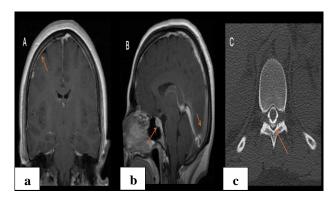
CSF leak-induced intracranial hypotension (a) post-contrast coronal T1 image shows smooth, diffuse pachymeningeal thickening characteristic of low-pressure headache, (b) post-contrast sagittal T1 image demonstrates classic findings of pituitary hyperemia, dilated venous sinuses, and cerebellar tonsillar descent measuring 7 mm, and (c) thoracic CT myelogram reveals posterior epidural contrast accumulation at T8-9 level, indicative of active CSF leak.
